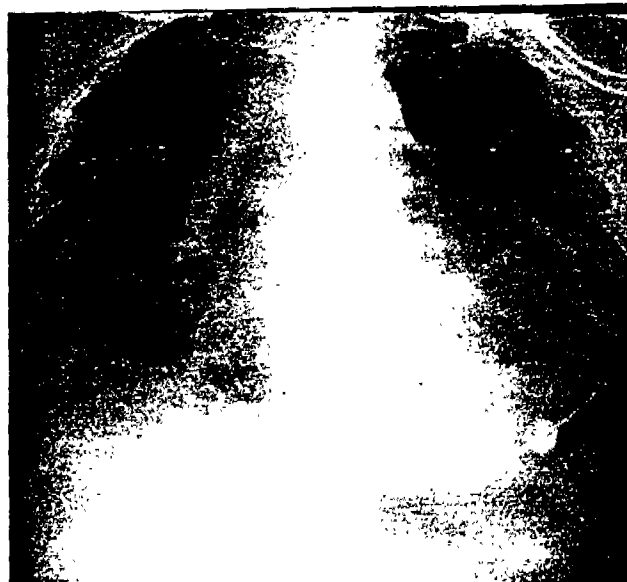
Portable supine chest roentgenogram demonstrating pneumopericardium.
